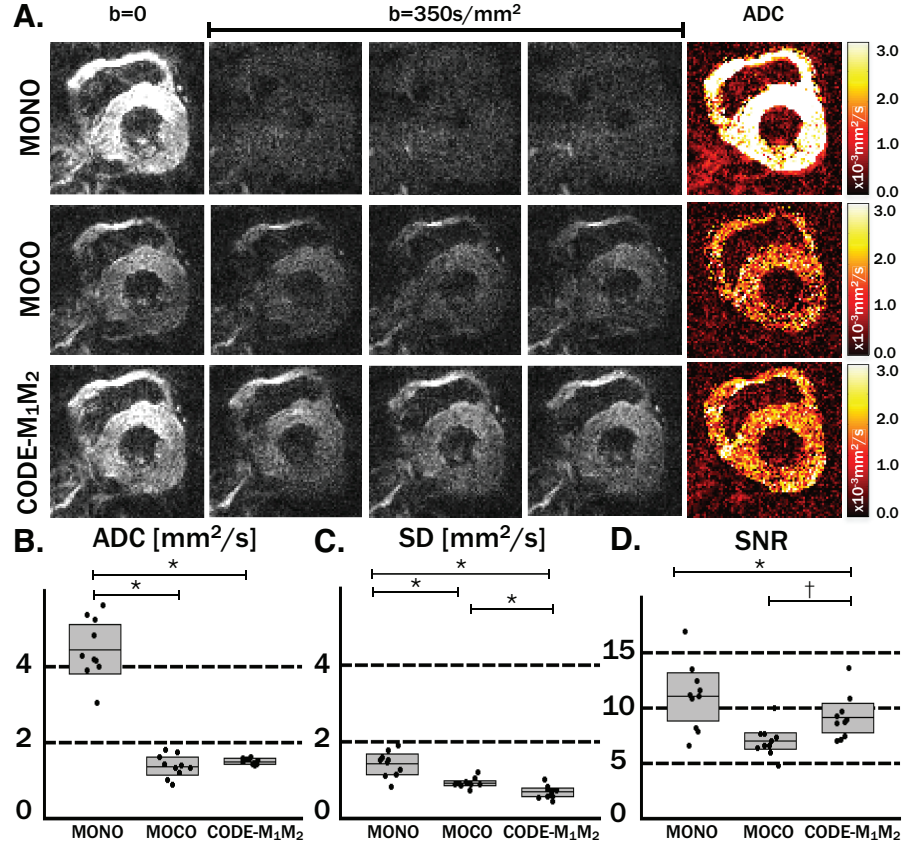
(A) Diffusion weighted images and ADC maps are shown from a typical healthy volunteer acquired at a single systolic cardiac phase with MONO, MOCO, and CODE-M₁M₂. MONO led to bulk motion corrupted DWI and subsequently elevated ADC maps while MOCO and CODE-M₁M₂ led to uncorrupted DWI and physiologically meaningful ADC values. (B) Mean septal ADC values were consistent between MOCO and CODE-M₁M₂, but much higher with MONO. CODE-M₁M₂ had less variability in mean ADC. (C) Standard deviations (SD) of the ADC within the septum were lower with CODE-M₁M₂ than MONO or MOCO. (D) SNR of the b=0 images was highest with MONO, but DWI were heavily corrupted. CODE-M₁M₂ had higher SNR than MOCO while maintaining bulk motion robustness.
